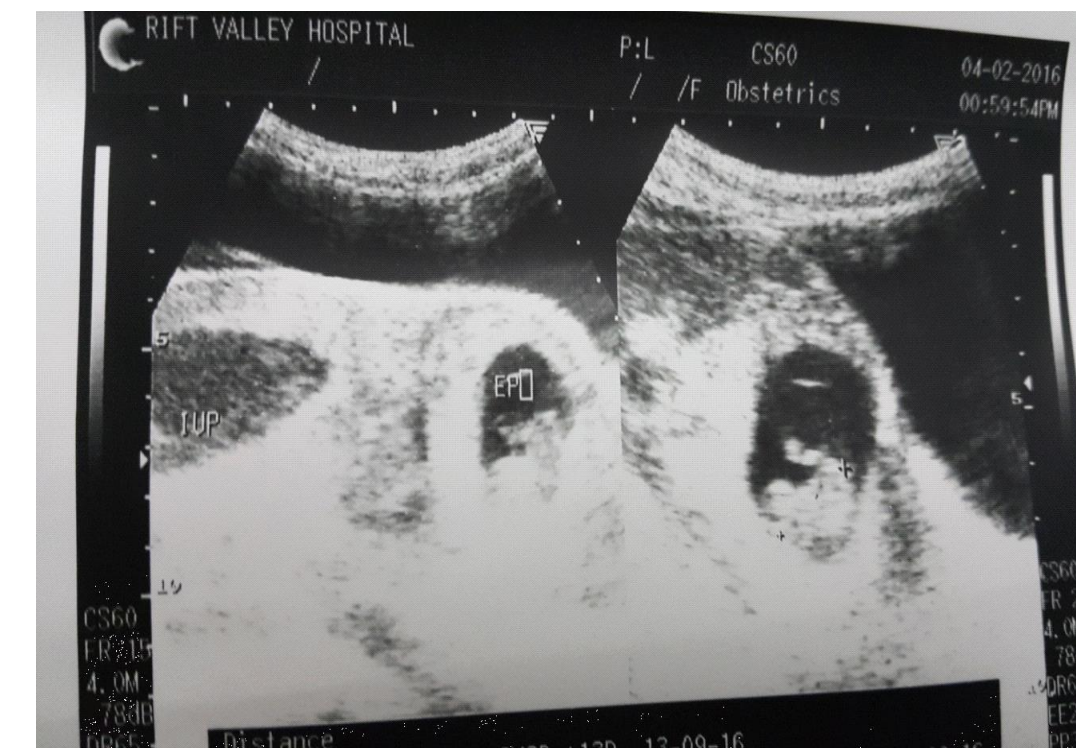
Trans abdominal ultrasound finding of Heterotopic pregnancy showing two separate gestational sacs; one of which is in the uterine cavity proper with no fetal heart beat, gestational age corresponding to 8 weeks + 2 days and the second pregnancy in left tube with positive fetal heart beat, with gestational age of 8 weeks + 5 days.
